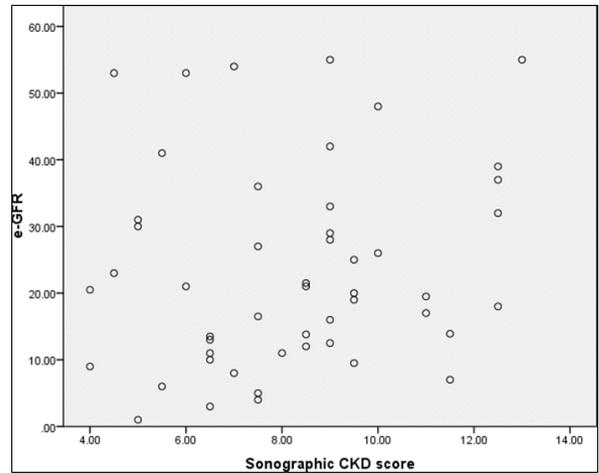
Correlation of e-GFR and sonographic CKD score
